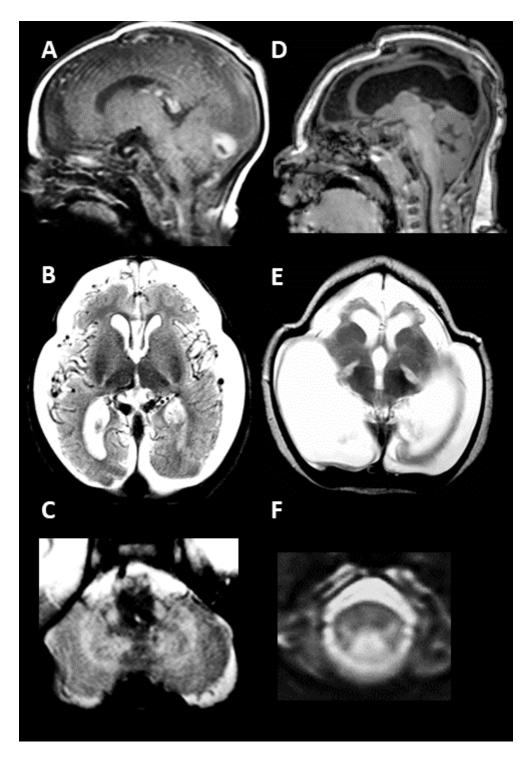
The MRI in a severe, early-onset form of LBSL at age two days (A, B, C) and age five months (D, E, F) shows striking progression of abnormalities. At two days, sagittal T_1 -weighted (A) and axial T_2 -weighted images (B) show hypoplasia of the cerebrum with numerous tortuous blood vessels on the surface of the brain (A, B). In the medulla, the inferior cerebellar peduncles and pyramids are clearly affected (C). At follow up, the cerebral mantle has been reduced to a thin rim, with degeneration of virtually all cortex and white matter (D, E). The tortuous vessels are no longer present. The posterior limb of the internal capsule is abnormal in signal (E). The axial image through the cervical spinal cord (F) shows signal abnormalities in the corticospinal tracts and dorsal columns.
